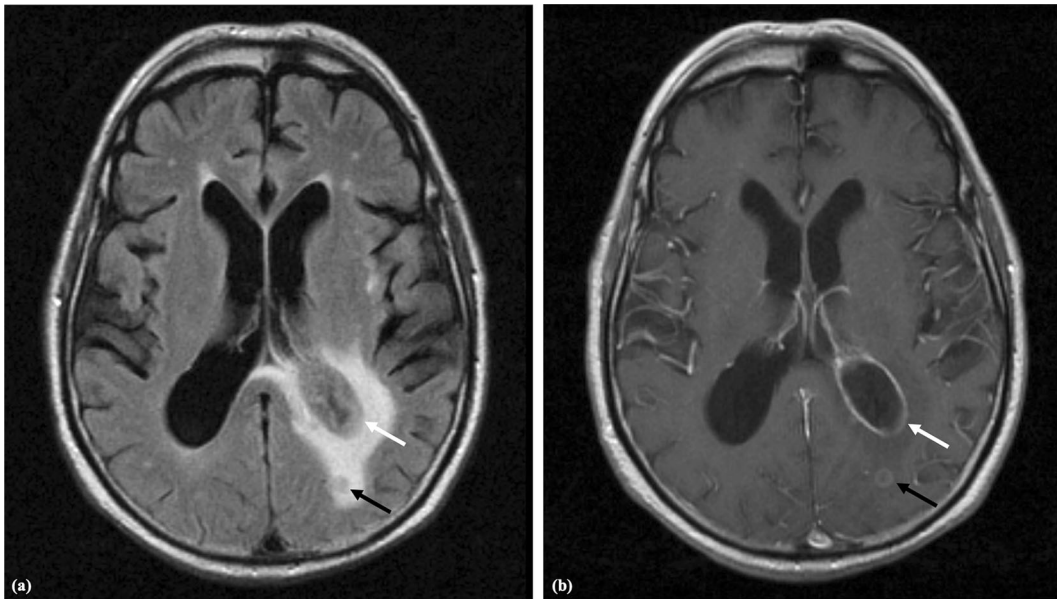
52-year-old female patient with prior history of heart transplantation and headache. Axial T2-weighted-fluid-attenuated inversion recovery (FLAIR) (a) and T1-weighted post-contrast (b) images demonstrate a small abscess in the left occipital lobe, with intermediate signal-intensity and ring enhancement
